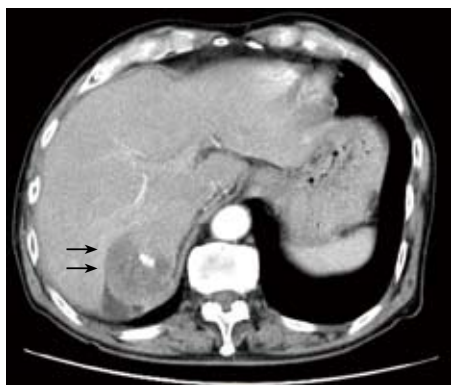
Computed tomography images showing a 7.5-cm liver tumor (arrows) arising from the caudate lobe in case 1(A), which appears to invade the transverse colon directly (arrows) (B).
